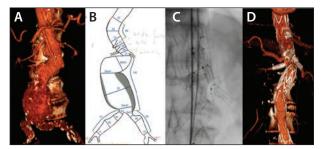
A juxtarenal AAA with severe angulation of the aorta above the aneurysm. Preoperative 3D CT (A). Preoperative sizing (B). Intraoperative view of the final position of the E-xtra DESIGN ENGINEERING stent graft and renal stents without any kinking (C). The postoperative 3D CT showed no leak and conformability of the E-xtra DESIGN ENGINEERING and bridging stents (D).
